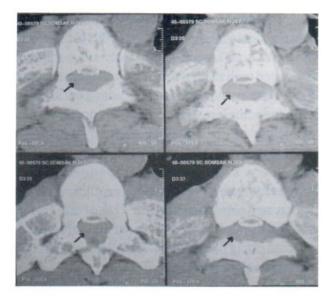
CT myelography in axial view shows extradural mass producing compression and anterior displacement of the spinal cord.
